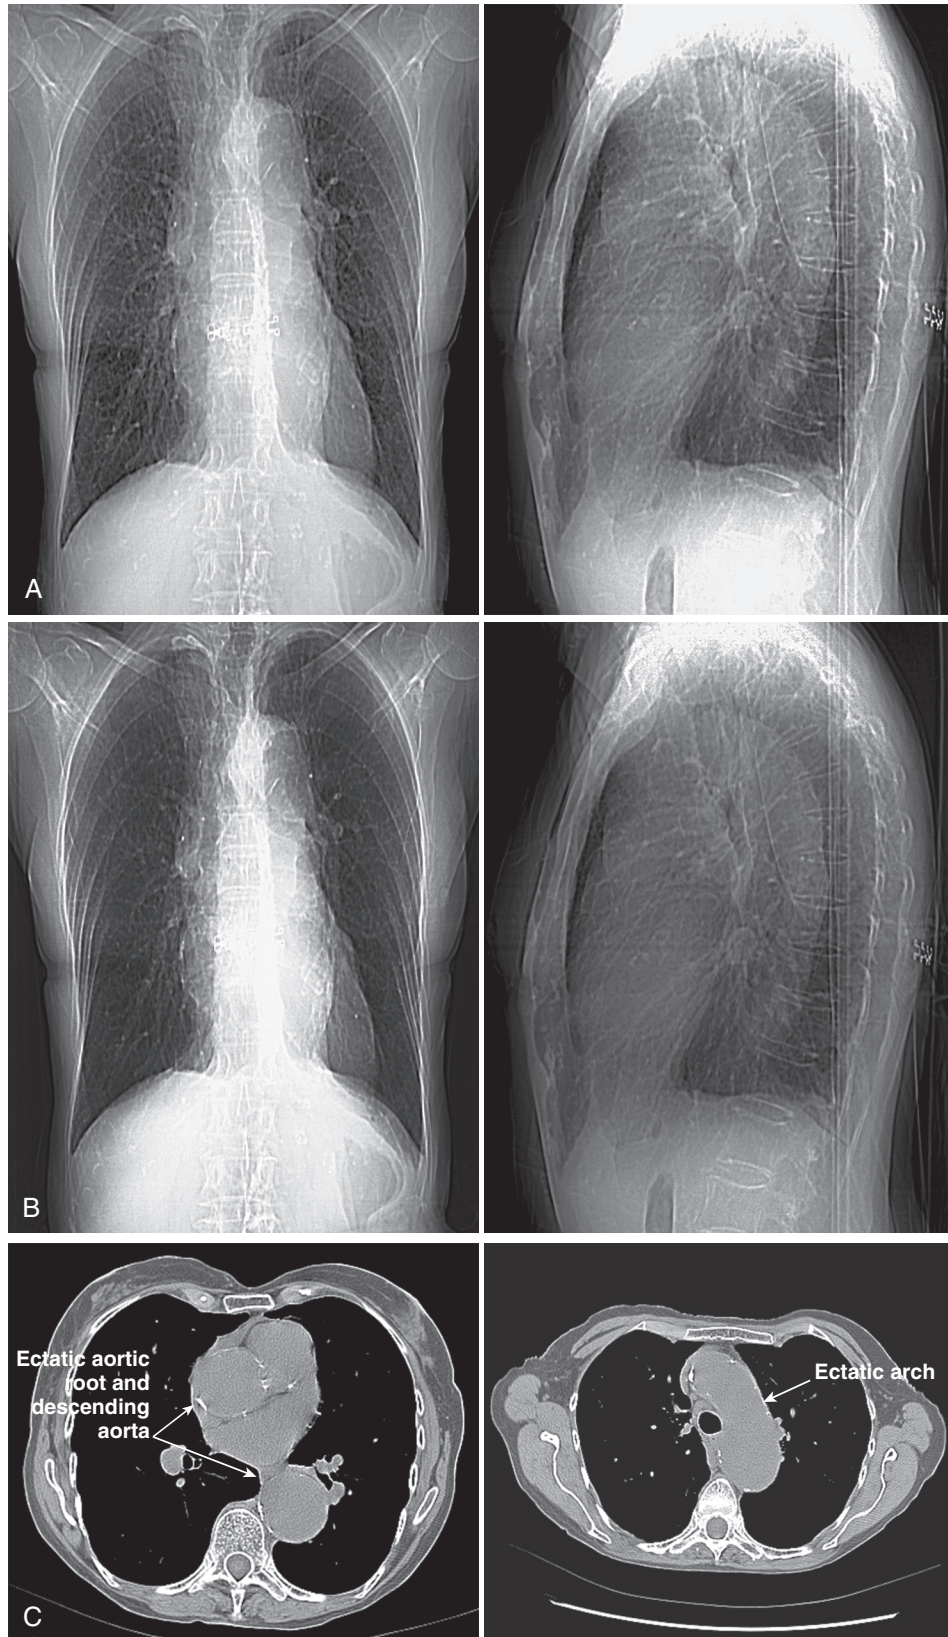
FIGURE e15-2 A, B, PA and lateral digital chest radiographs with different windows and leveling. A, With a pulmonary window and leveling, the lung fields, including the pulmonary vasculature, are well visualized but the mediastinal structures are not well defined. Note also flattening of the diaphragms and increased lung lucency, indicative of chronic obstructive pulmonary disease. B, Rewindowed, the mediastinal structures are now well seen and show a dilated, calcified aortic root and descending thoracic aorta. Pulmonary vascularity cannot be defined in these images. C, CT scan at the level of the aortic root and arch confirming the marked ectasia of the entire thoracic aorta.
